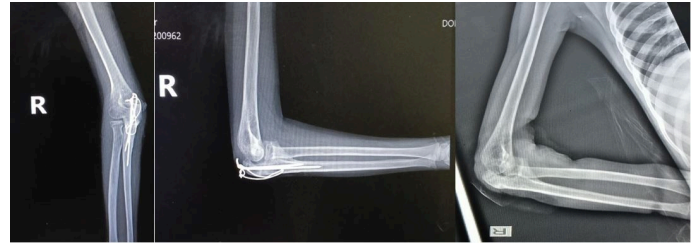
A and B Follow up xray at 4 months, C- After implant removal at 5 months
